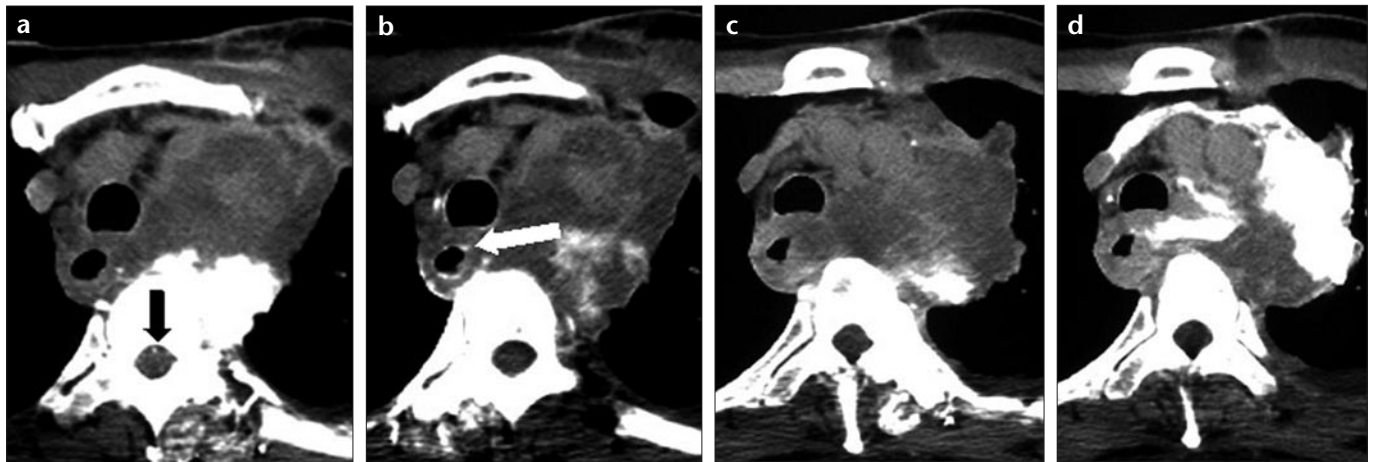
a-d. Patient no 5. Selective CT angiogram via the left first intercostal artery (a), right second intercostal artery (b), left third intercostal artery (c), and left bronchial artery (d). The anterior spinal artery is visualized by selective CT angiogram via the left first intercostal artery (a, black arrow). Esophageal wall enhancement via the right second intercostal artery is seen (b, white arrow).
